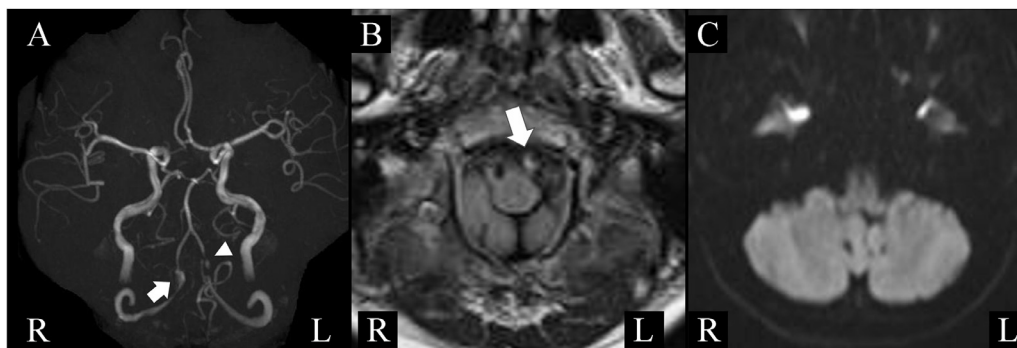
Initial head MRI. (A) MRA: Wall irregularity is observed in the left vertebral artery near the bifurcation of the posterior inferior cerebellar artery (arrow head). A fusiform aneurysm is observed in the right vertebral artery. (arrow). (B) FLAIR: High signal is observed in the left vertebral artery. (arrow). (C) Diffusion-weighted image: No obvious infarction is found in the brainstem and cerebellum. MRI, magnetic resonance imaging; MRA, magnetic resonance angiography; FLAIR, fluid-attenuated inversion recovery.
